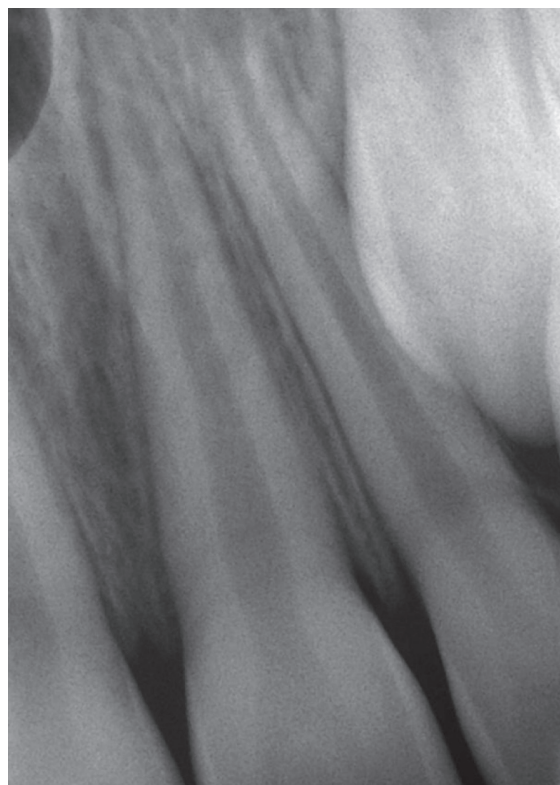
X-ray of tooth 21 after correction of tooth replantation performed in the dentist's office.
